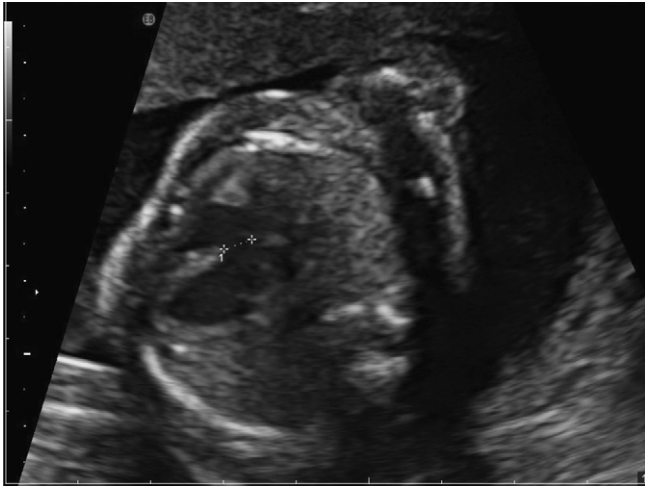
Prenatal ultrasound demonstration of ventricular septal defect.
